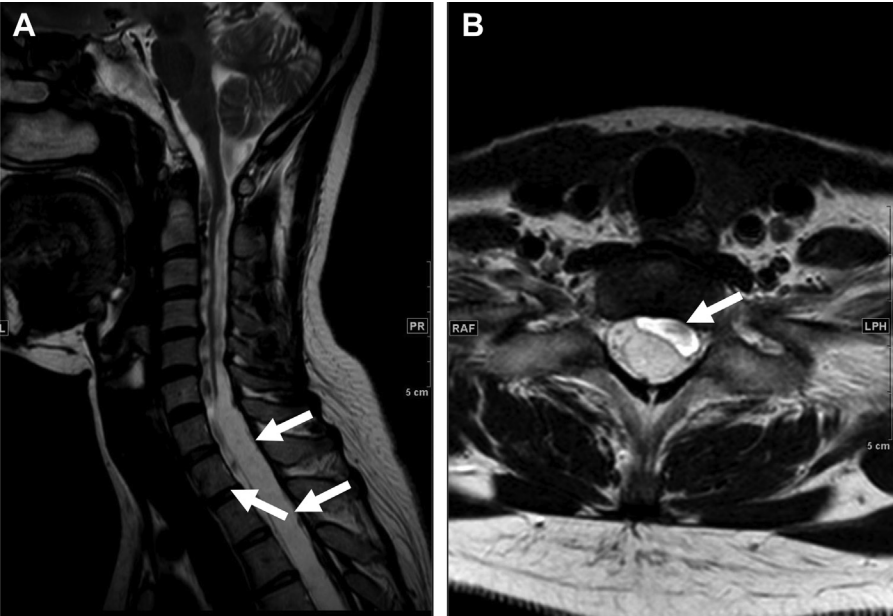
Chronic arachnoiditis after remote TB spinal meningitis. Sagittal T2-weighted MR imaging (A) and axial T2-weighted MR imaging (B) show a syrinx formation in the cervicothoracic spinal cord with arachnoid cysts (arrows).
